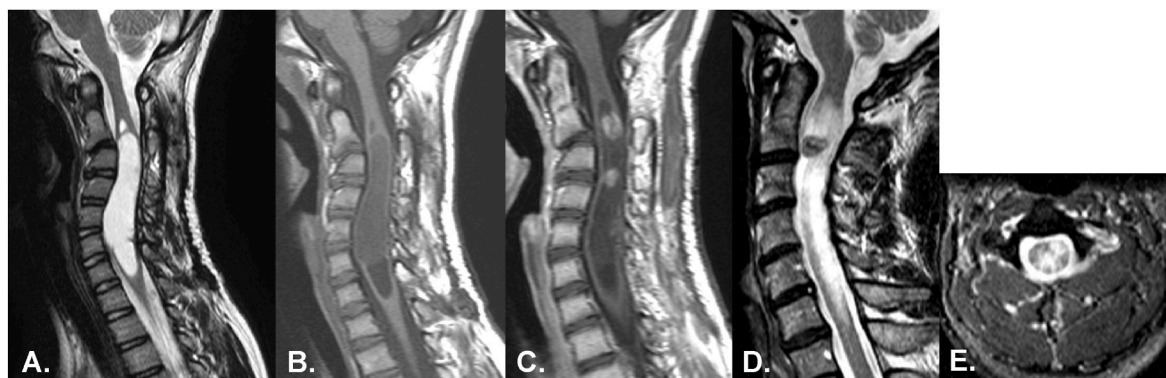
Comparison of pediatric and adult pilocytic astrocytomas. A. and D. Sagittal T2-WI. B. Sagittal T1-WI. C. Sagittal post-gadolinium T1-WI. E. Axial T2-WI. Pediatric case: MRI reveals an intramedullary tumor mass with multiple cysts extending from C2 to C7 without any surrounding edema (A, B). The solid component of the astrocytoma shows contrast enhancement (C). Adult case: MRI demonstrates extensive vasogenic edema surrounding the pilocytic astrocytoma extending from C2 to C7 on sagittal and axial planes (D, E). Legend: WI = weighted image.
